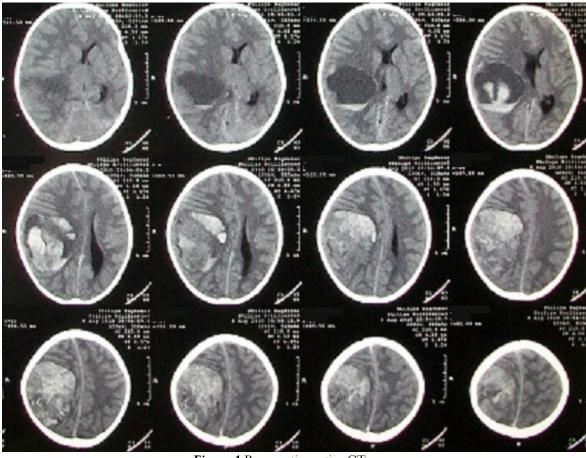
Preoperative native CT-scan
